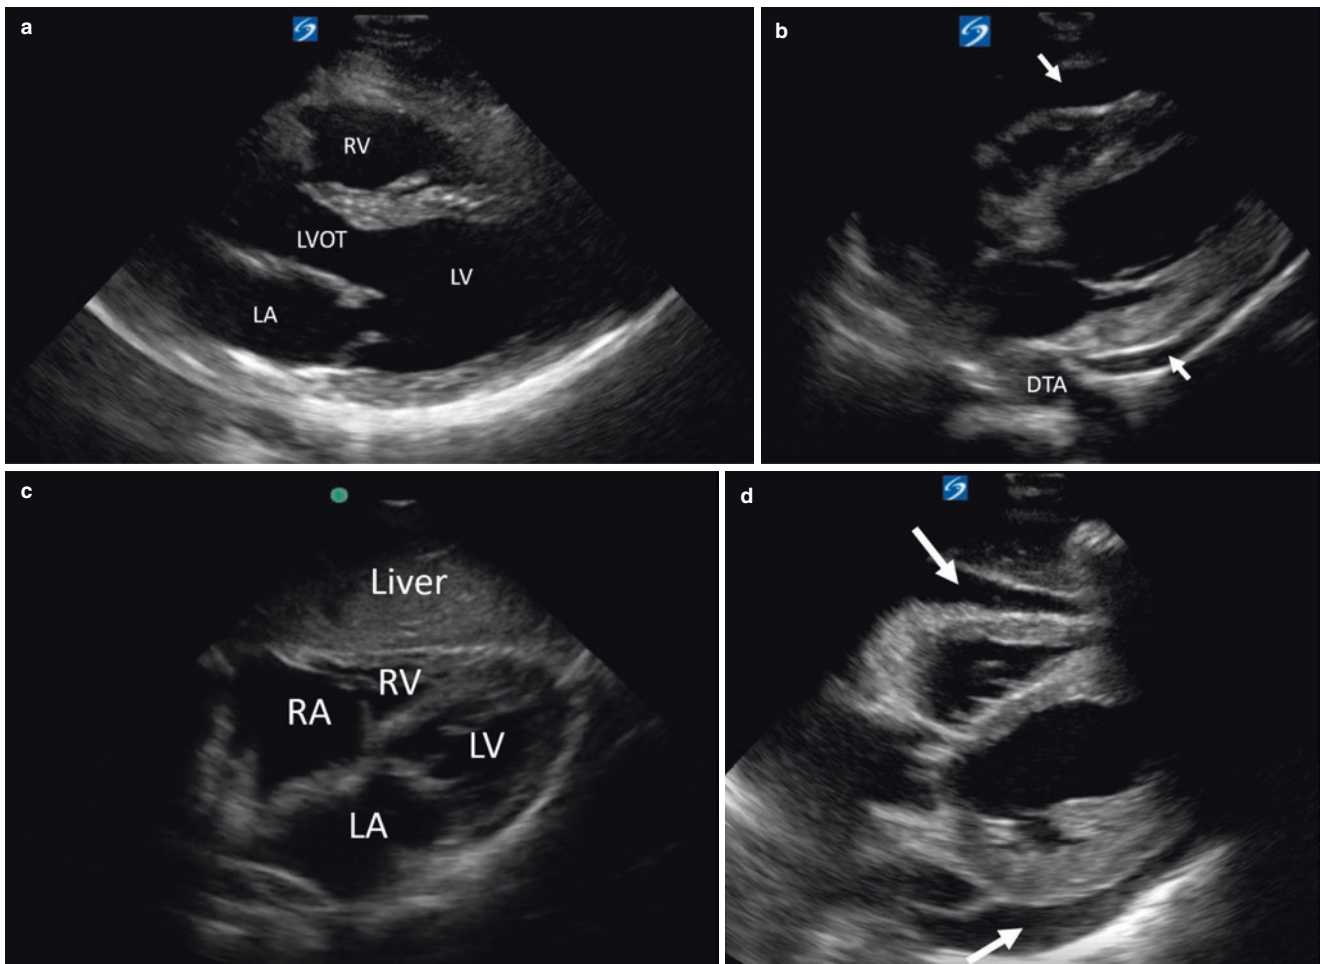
Parasternal and subxiphoid views of the heart. (a) Normal parasternal long-axis view. (b) Parasternal long axis with circumferential pericardial effusion (*arrows*). (c) Normal subxiphoid view. (d)
